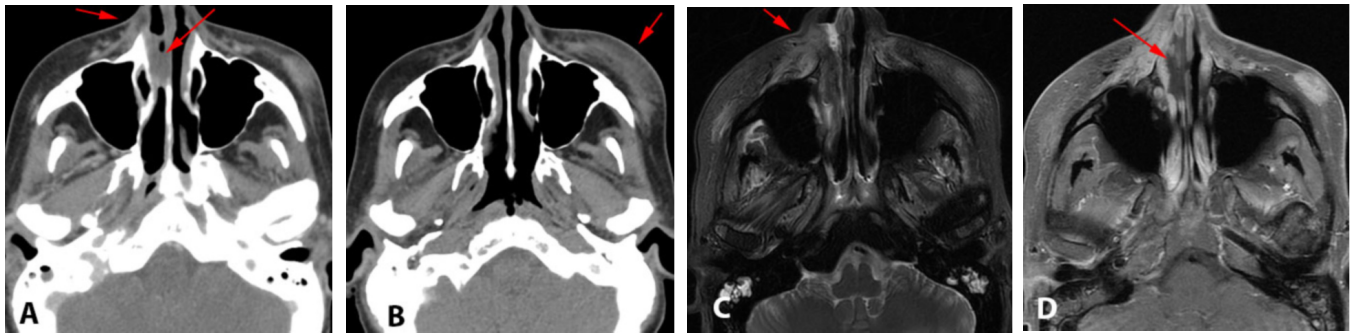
39-year-old female with refractory AML in blast crisis presented with nasal drainage unresponsive to antibiotic treatment. (A) Noncontrast sinus CT demonstrates an opacified right-nasal-cavity and subtle right-orofacial soft-tissue infiltration (arrow) with adjacent nasal-cavity mucosal edema. (B) Noncontrast facial CT performed for trauma two weeks earlier demonstrates a hematoma (arrow), but normal orofacial soft tissue. (C) T2-weighted and (D) T1-weighted post-gadolinium, fat-saturated MRI performed on Day 2 demonstrates progression, with worsening orofacial soft-tissue infiltration and nonenhancing nasal cavity mucosa (arrows).
